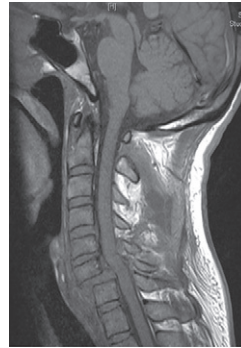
MRI of the same patient
